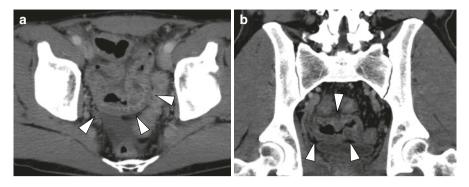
Enhanced CT images in a patient with IgA vasculitis. (a, b) Wall thickness of the terminal ileum is shown (arrowheads)
